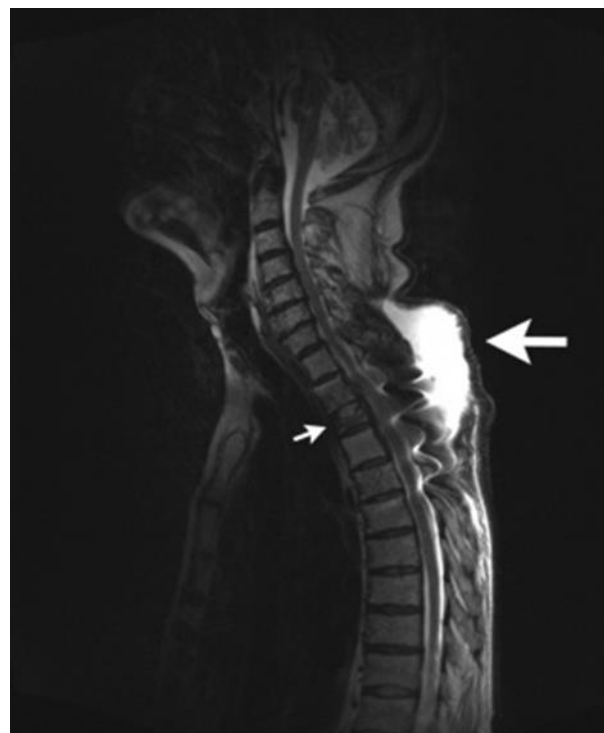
MRI of the thoracic spine (T2-weighted, sagittal reconstruction).
